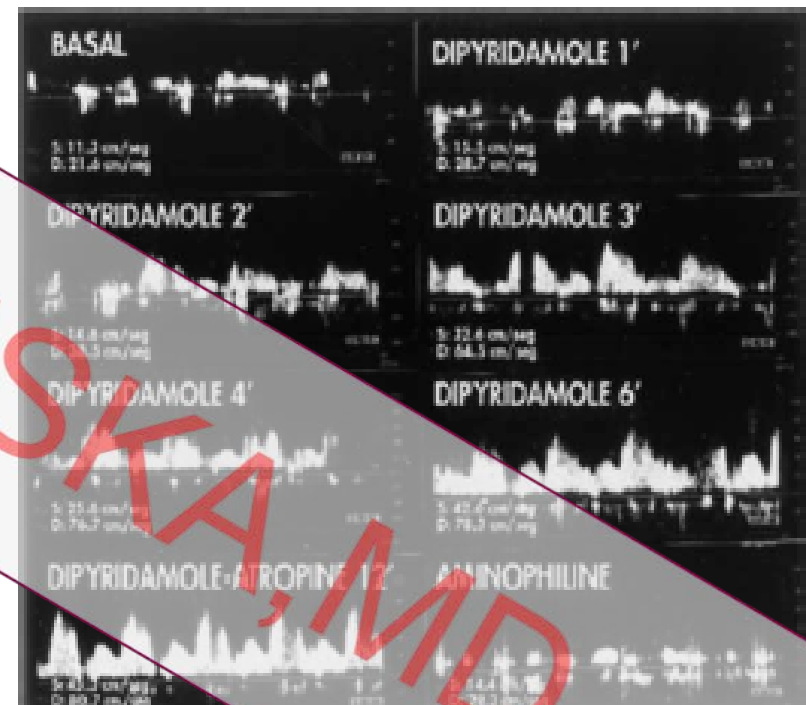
Temporal sampling of coronary flow reserve (CFR) by transthoracic echocardiography. There is progressive, stepwise increase in CFR peaking after high dose and immediately reversed on aminophylline administration.
